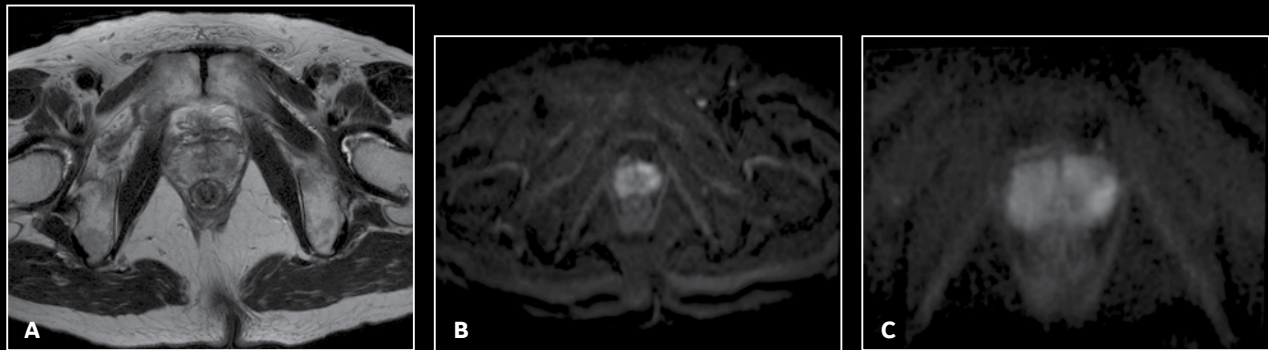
Prostate cancer patient (A) Axial T2w PROPELLER MB, 0.6 x 0.7 x 4 mm, 3:25 min.; (B) EPI DWI b1000, 2.3 x 2.3 x 4 mm, 2:08 min.; and (C) FOCUS DWI, b1000, 1.5 x 1.5 x 4 mm, 4:10 min.
